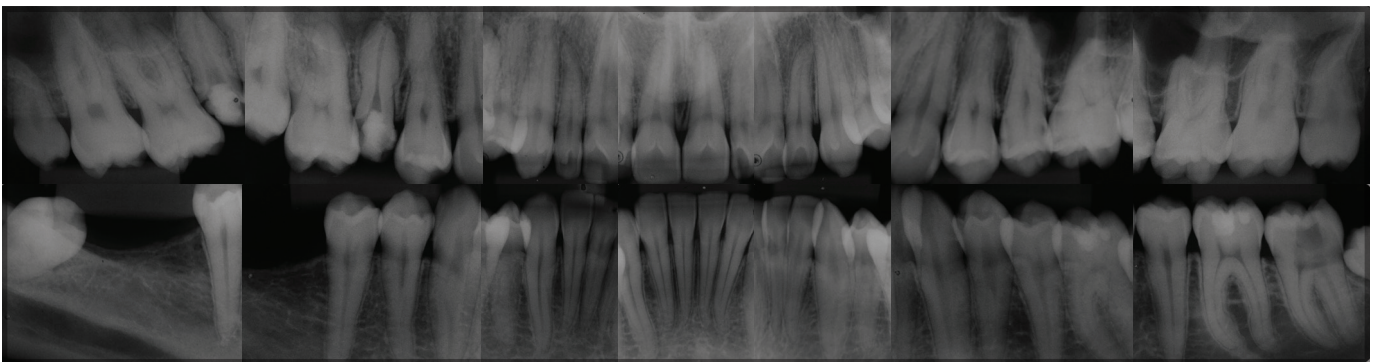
Radiographic evaluation at the fourth appointment, revealing no interproximal bone loss.
